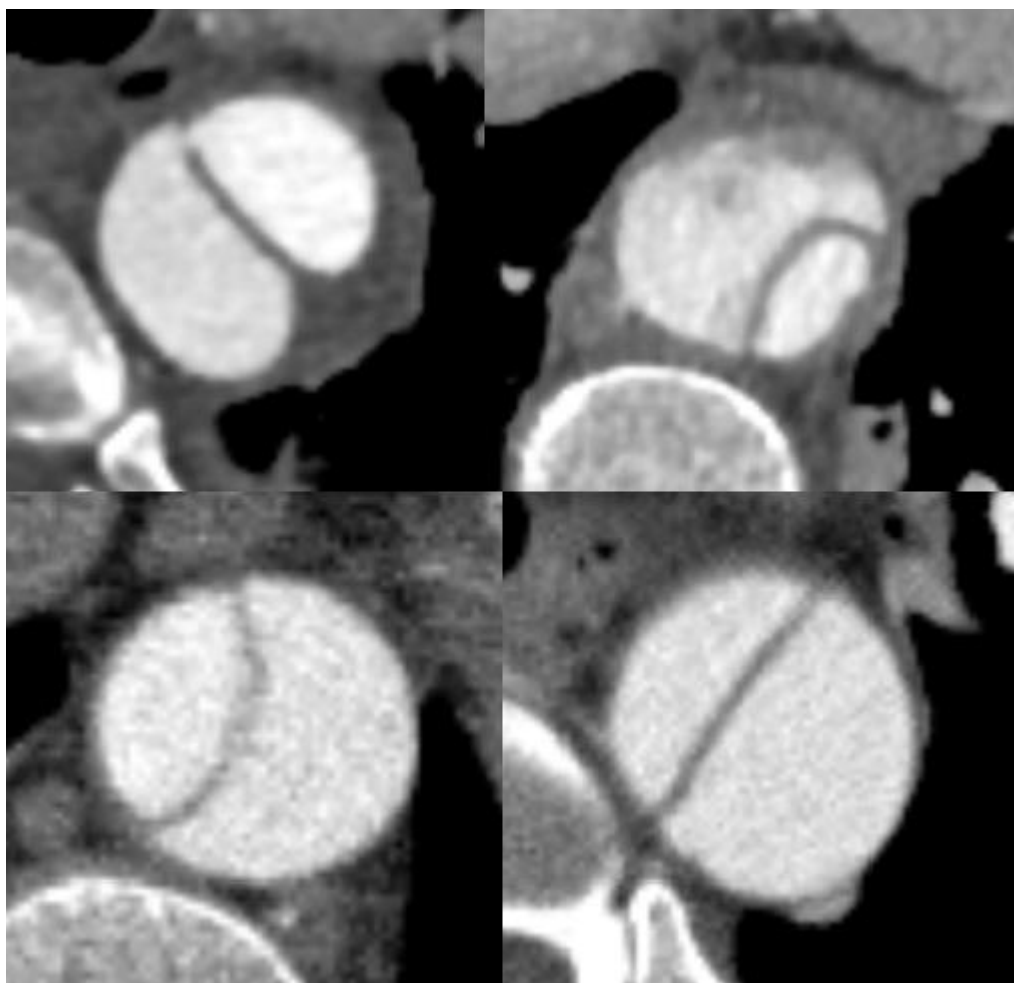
Middle segment of the aorta in selected patient 1 and patient 2. Patient 1 had uneven distribution of contrast enhancement between true and false lumen (upper left) and blurred aorta borders (upper right). Patient 2 had more complete performance of aorta CTA image than Patient 1 (lower left and right).
